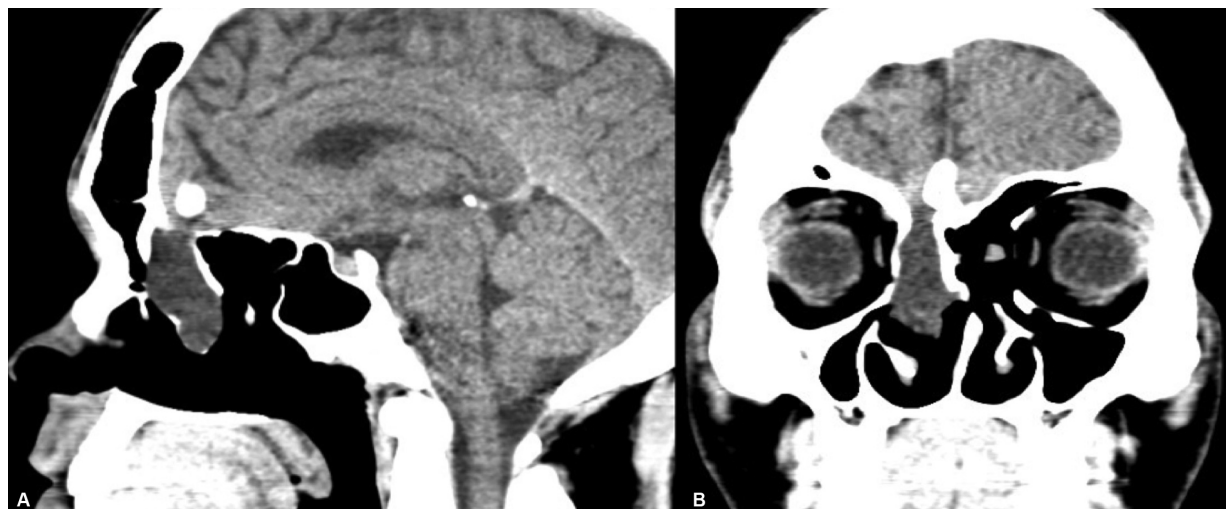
A and B - Head computed tomography shown in sagittal and coronal sequences with an anterior skull base encephalocele with large bone defect connecting the intracranial anterior floor with the nasal region.
